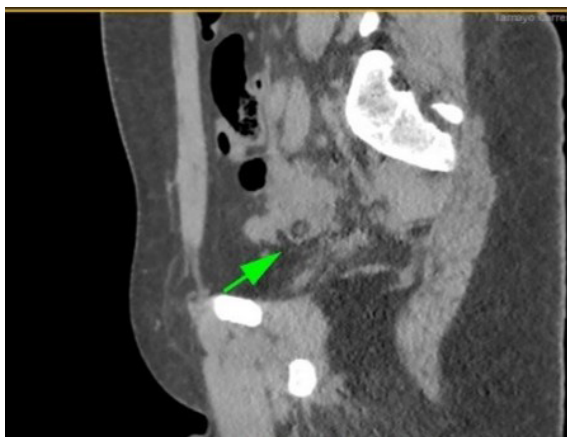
ABDOMINAL-PELVIC COMPUTED TOMOGRAPHY SCAN SHOWING A LEFT ADNEXAL MASS WITH A SOLID COMPONENT AND INTERNAL CALCIFICATIONS, CONSISTENT WITH A MATURE OVARIAN TERATOMA
